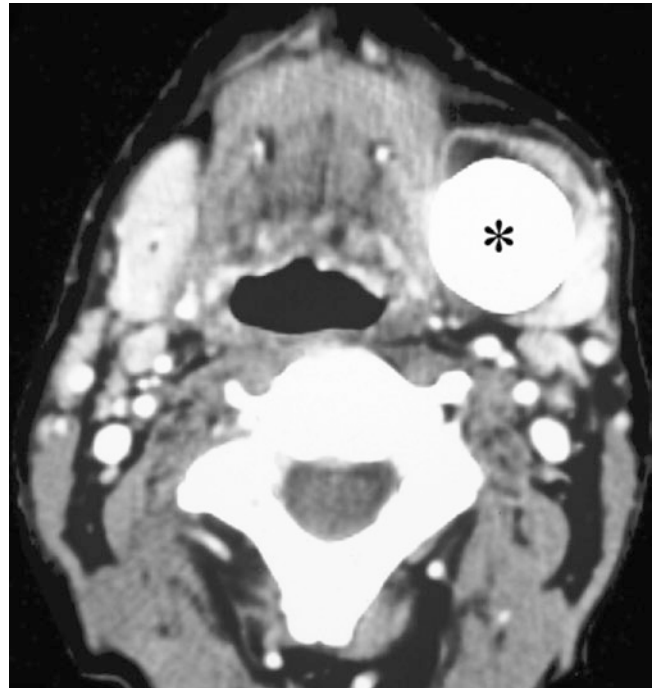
Submandibular gland stone; 61-year-old male, heavy drinking smoker, with incidental finding of a hard submandibular mass, which had been painless for more than 10 years; question of oral cancer in soft palate. Axial post-contrast CT image shows large stone in submandibular gland (*asterisk*)
